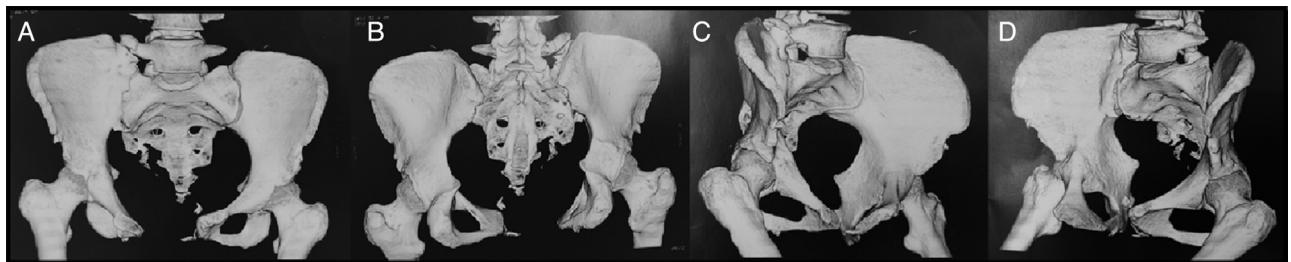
Three-dimensional computed tomography reconstruction two years after the trauma. (A) Anterior view; (B) posterior view; (C) left wing view; (D) right wing view.
